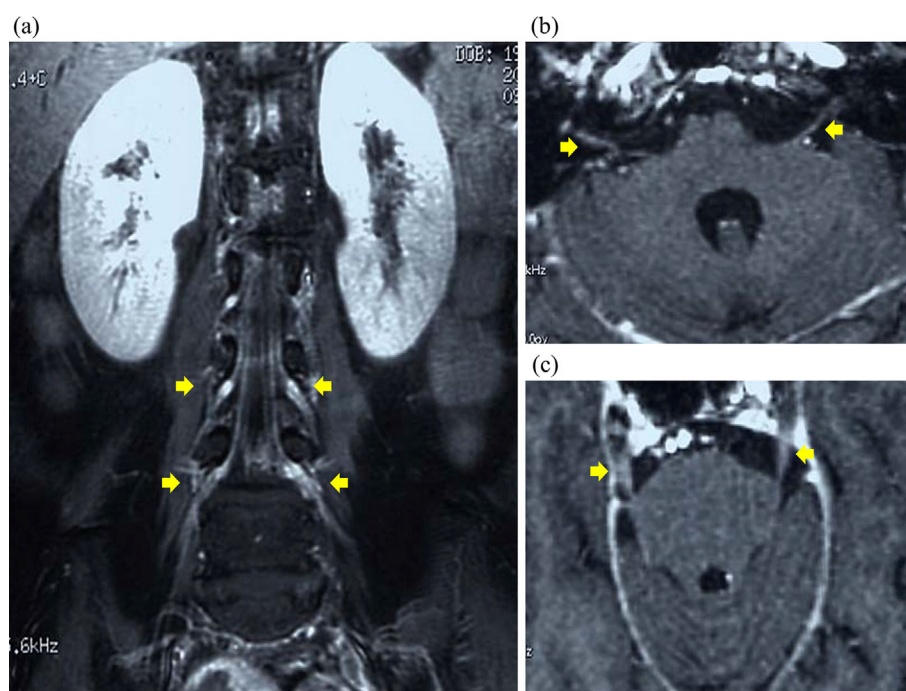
The MRI findings. T1-weighted MRI with contrast agent in the most advanced stage at 7 months from admission. Enhancement was clearly observed (a) in the lumbar nerve root and nerve (a), the facial nerve (b) and the trigeminal nerves (c) (arrows).
